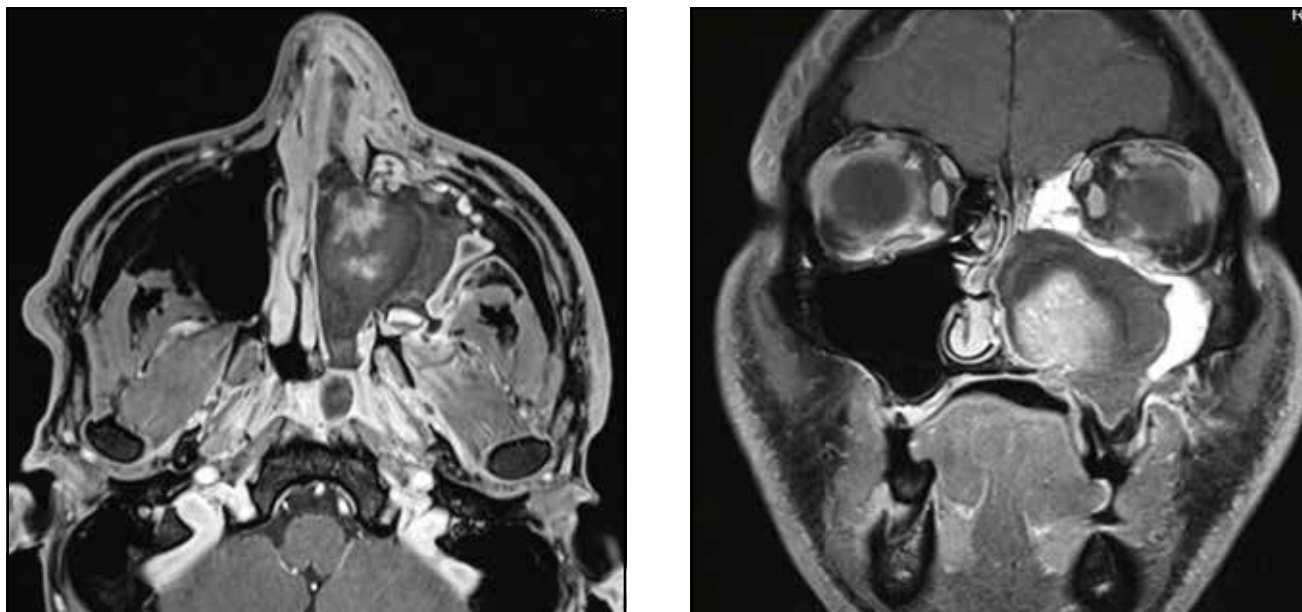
One and a half months after the first surgery: Contrast-enhanced cranio-cerebral MRI (T1 and T2 signal axial and coronal sections) revealed the tumor reoccupied the left nasal fossa and the left maxillary sinus.
